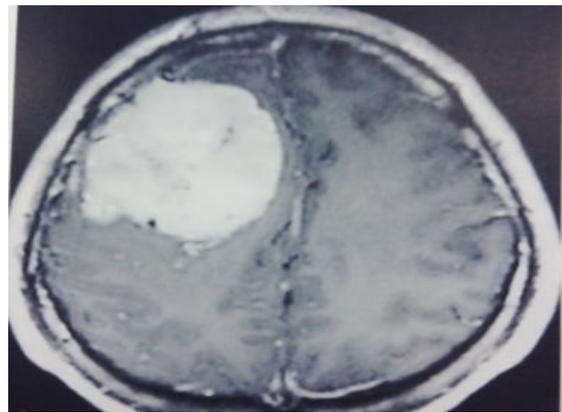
Post-contrast axial T1-weighted MRI image show a parietal extra-axial mass showing strong enhancement with contrast administration.
